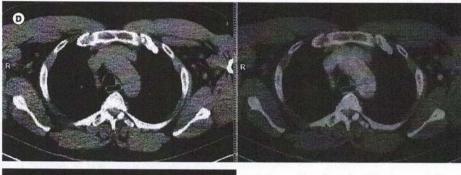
(D) PET/CT of moderately active left axillary lymph nodes; (E) PET/CT – an enlarged and moderately active left iliac LN
